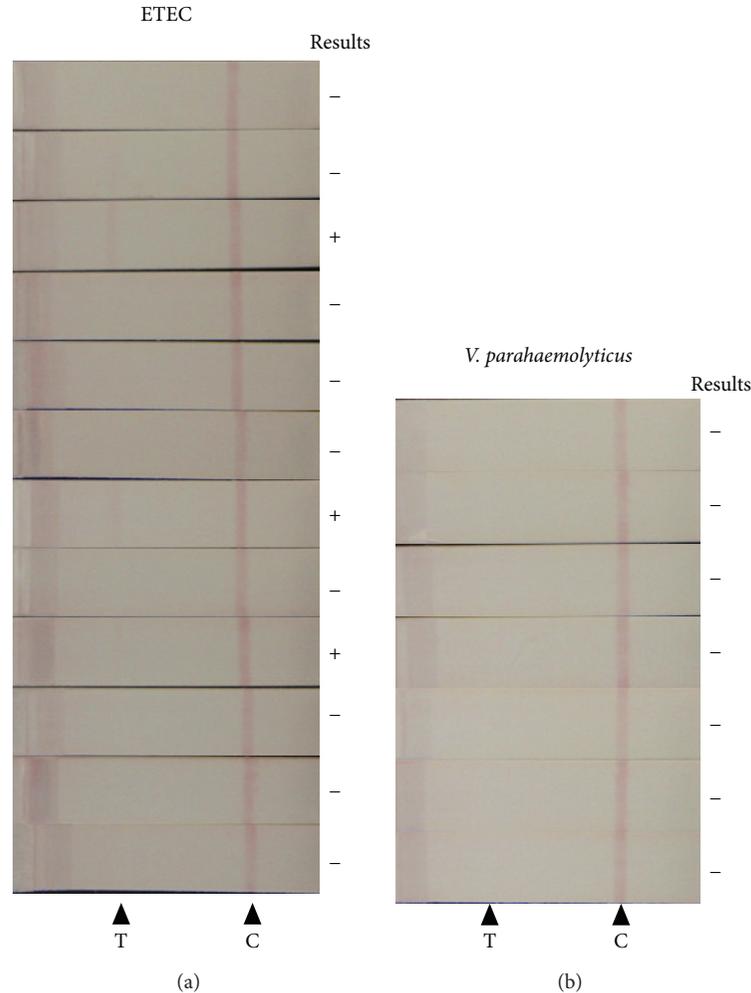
Reactivity of CT-IC with non-*V. cholerae* strains. Twelve ETEC isolates (a) and 7 *V. parahaemolyticus* isolates (b) were cultured under AKI-SW condition, and then obtained supernatants of each culture were examined by CT-IC. The “+” or “-” symbols were placed on the left side of the strips developing “faint” or “no” bands at test lines, respectively. T: test line, C: control line.
